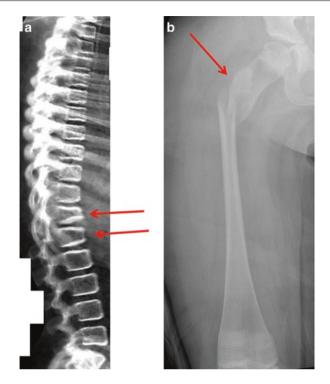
A 10-year-old patient with Duchenne muscular dystrophy, who was treated with prednisone (0.75 mg/kg/day) since the age of 6 years, developed back pain. There was no history of trauma, and he was independently ambulant at the time. His lumbar spine (L1-L4) DXA measured bone mineral apparent (BMAD) Z-score was -1.6. Thoracolumbar radiographs of the spine showed compression fractures of T12 and L1 vertebral bodies. He was treated with 3-month intravenous pamidronate (total annual dose 12 mg/kg). His back pain resolved rapidly. Vertebral fracture assessment (VFA) by DXA (a) shows partial reshaping of fractured T12 and L1 vertebral bodies, 3 years after treatment with intravenous pamidronate. Note sclerosis of vertebral endplates as the result of pamidronate therapy. At the age of 14 years, when his mobility was declining, he slipped and fell on the bathroom floor, sustaining fracture of the proximal shaft of his right femur (b)
